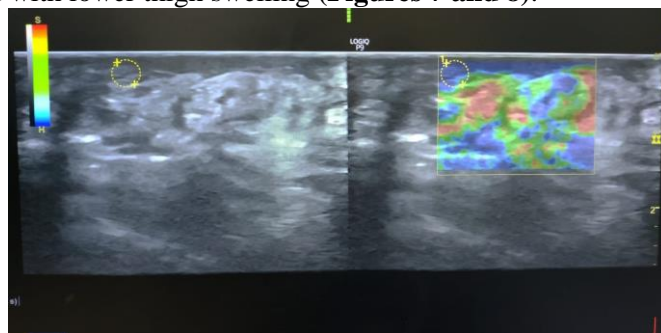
Ultrasound elastography shows: E1/E2 ratio 4.7
